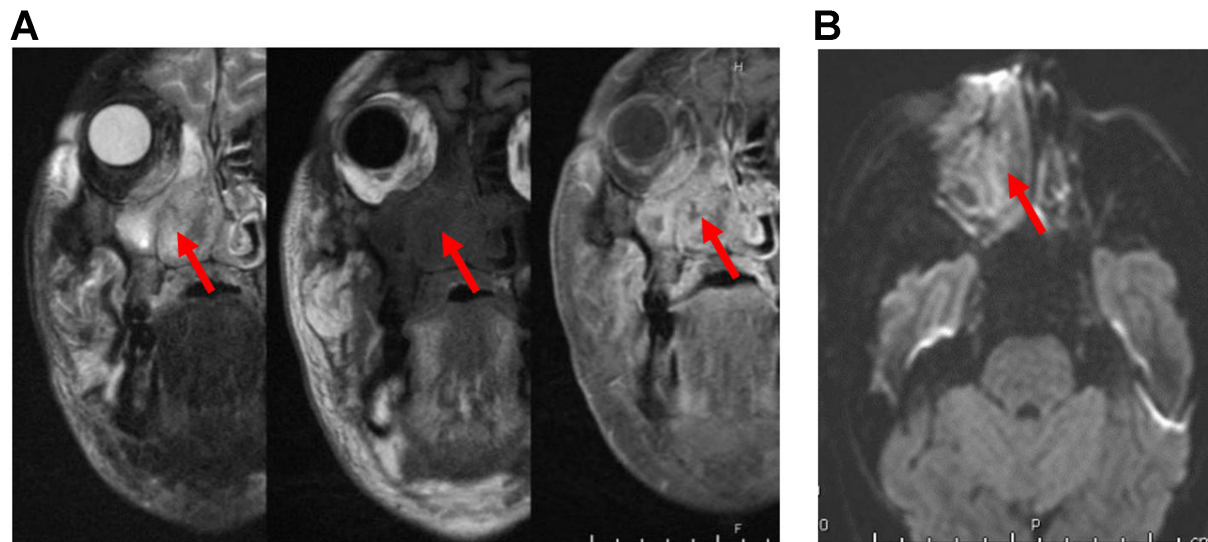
Sinonasal lymphoma. (A) Coronal MRI images (from left to right: T2, precontrast T1, and post-contrast T1) show an ill-defined, trans-spatial lesion with intermediate T1/T2 signal intensity and heterogeneous enhancement. The lesion extends along the nasal cavity, maxillary sinus wall, maxillary alveolus, and hard palate, with invasion of the adjacent medial right orbit and extensive stranding of the facial soft tissues (arrows); (B) Axial DWI images demonstrate a hyperintense signal (arrow), confirmed to represent restricted diffusion on the corresponding ADC maps (not shown). MRI: Magnetic resonance imaging; DWI: diffusion-weighted imaging; ADC: apparent diffusion coefficient.
